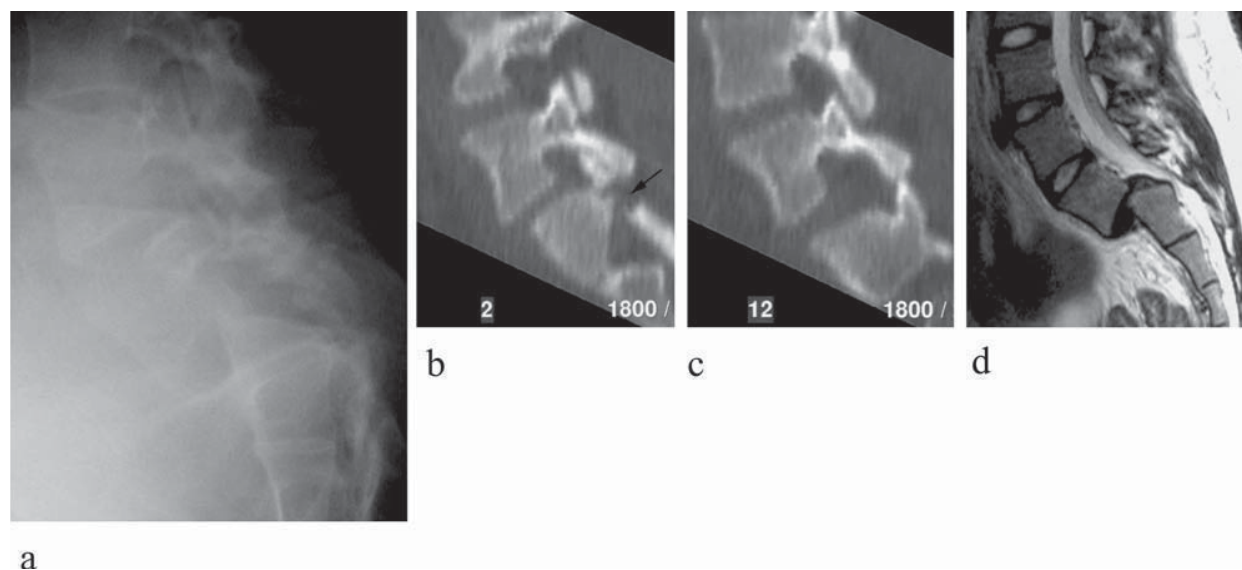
Patient 1. Delayed imaging. a: Lateral radiograph of the lumbosacral junction shows Grade 4 L5–S1 spondylolisthesis. b: CT of the lumbosacral junction. Right parasagittal multiplanar reconstruction showing fracture of the S1 superior articular facet (arrow). c: CT of the lumbosacral junction. Left parasagittal multiplanar reconstruction showing dislocation of the left L5–S1 facet joint. d: Sagittal T2-weighted MRI demonstrates Grade 4 L5–S1 traumatic spondylolisthesis with compression of the cauda equina and degeneration of the L5–S1 disc.
